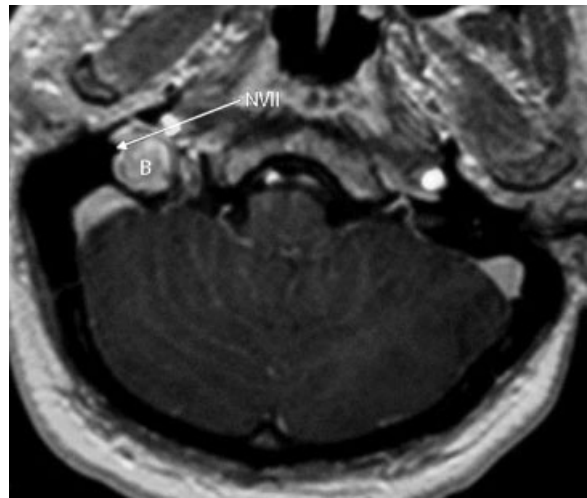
MRI T1 axial scan (equivalent plain): contrast-enhanced, HJB (B) protruding into tympanic cavity, mastoid segment of facial nerve (N VII).
